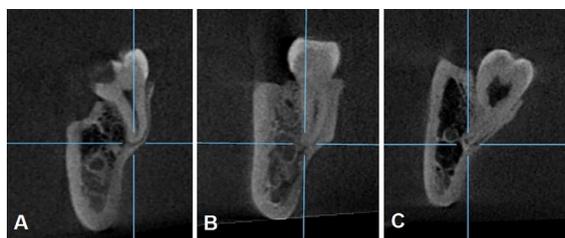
Cone beam computed tomography images showing the vertical relationship of the mandibular canal classified as “distant” (A), “in contact” (B), and “adjacent to the third molar root” (C).
